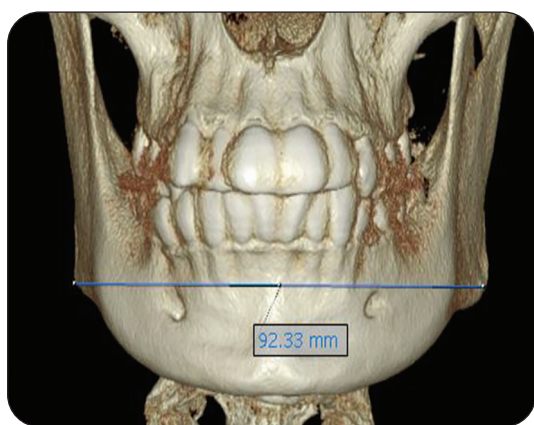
Forontal reconstructed CBCT 3D image showing linear measurement of bigonial distance
